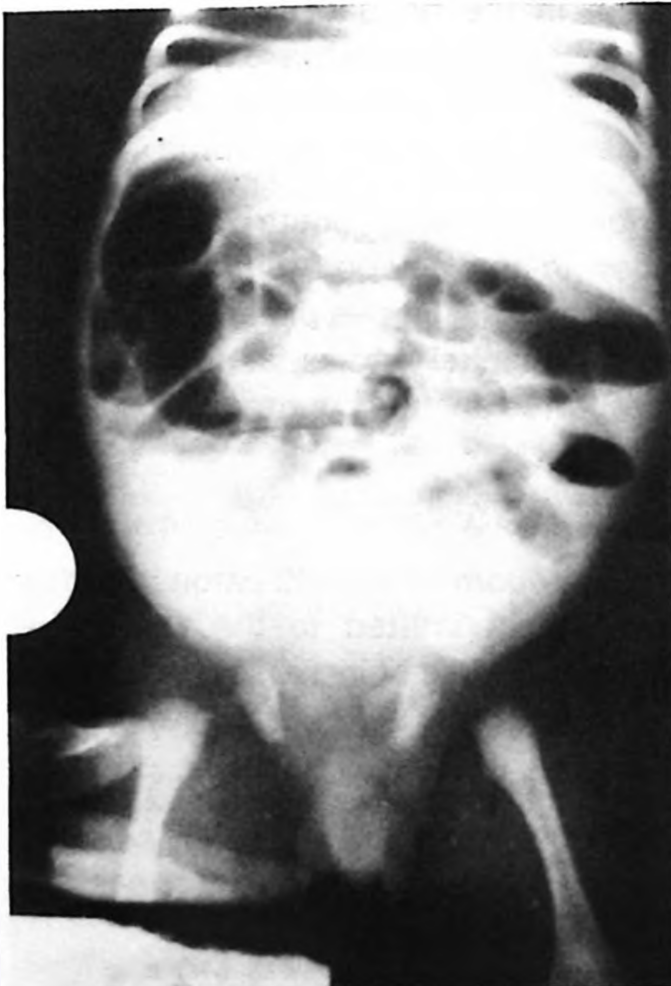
Plain erect radiograph on admission.
